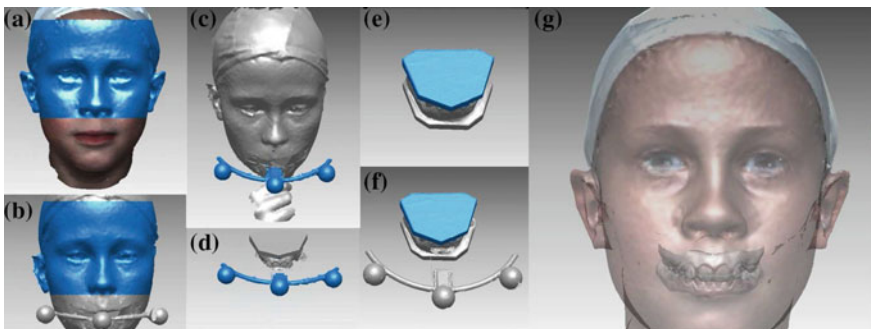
Acquisition of a 3D surfaces from CBCT; b, c mandible movement using modified 3dMD scanner; d virt. dental models with arches from Minolta VI-9i scanner
